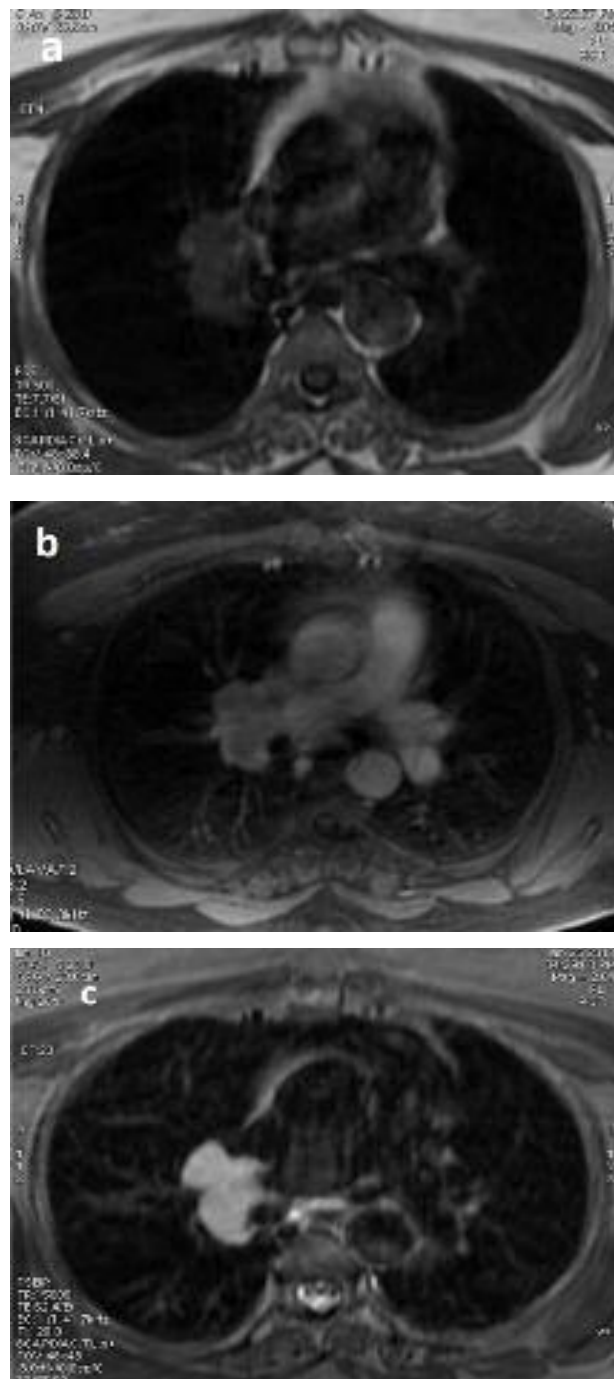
(a) Axial T1 weighted and (b) contrast T1-weighted fat-saturated MR imaging demonstrates the right hilar mass with avid enhancement. (c): Axial T2 weighted MR imaging shows homogenous T2 hyperintensity.
